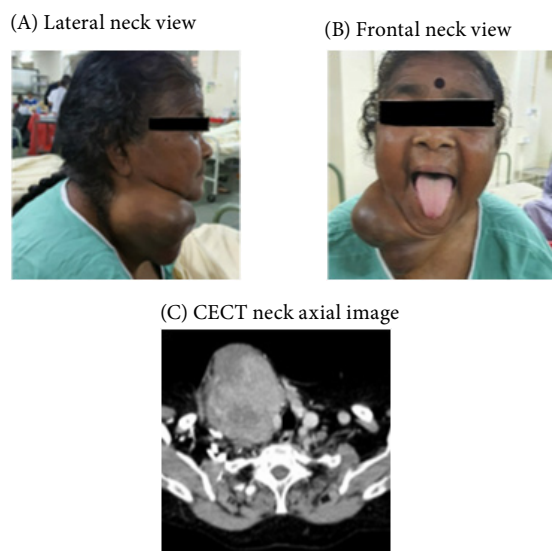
(A) Frontal and (B) lateral clinical photographs showing a large right-sided thyroid swelling with significant anterior neck distortion in case 4. (C) Axial contrast-enhanced computed tomography (CECT) image demonstrating a large thyroid mass causing leftward deviation of the trachea with compression of adjacent soft tissue structures.
